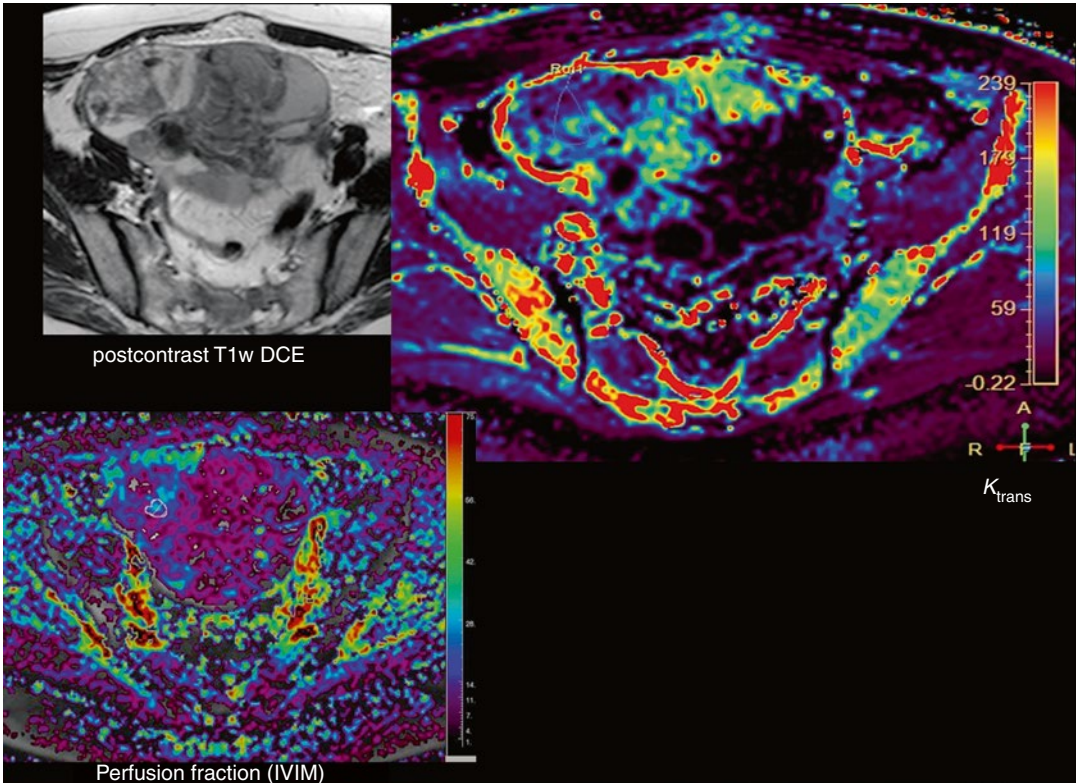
Right ovarian cystoadenocarcinoma. Large heterogenous mass on post-contrast T1-weighted sequence which shows elevated K^{trans} values on solid areas
